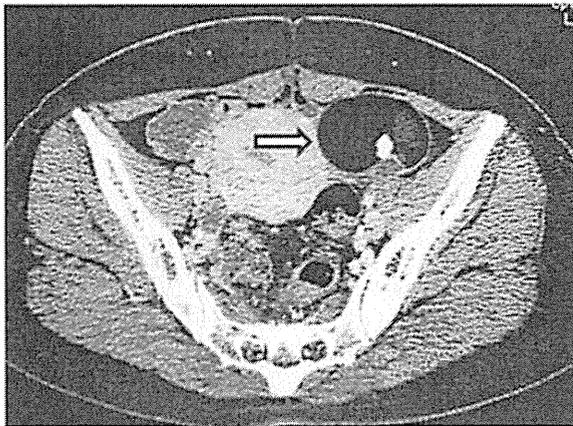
Enhanced abdominal CT showing a calcification and fatty tissue in the pelvic tumor, suggesting a typical mature cystic teratoma (arrow).
